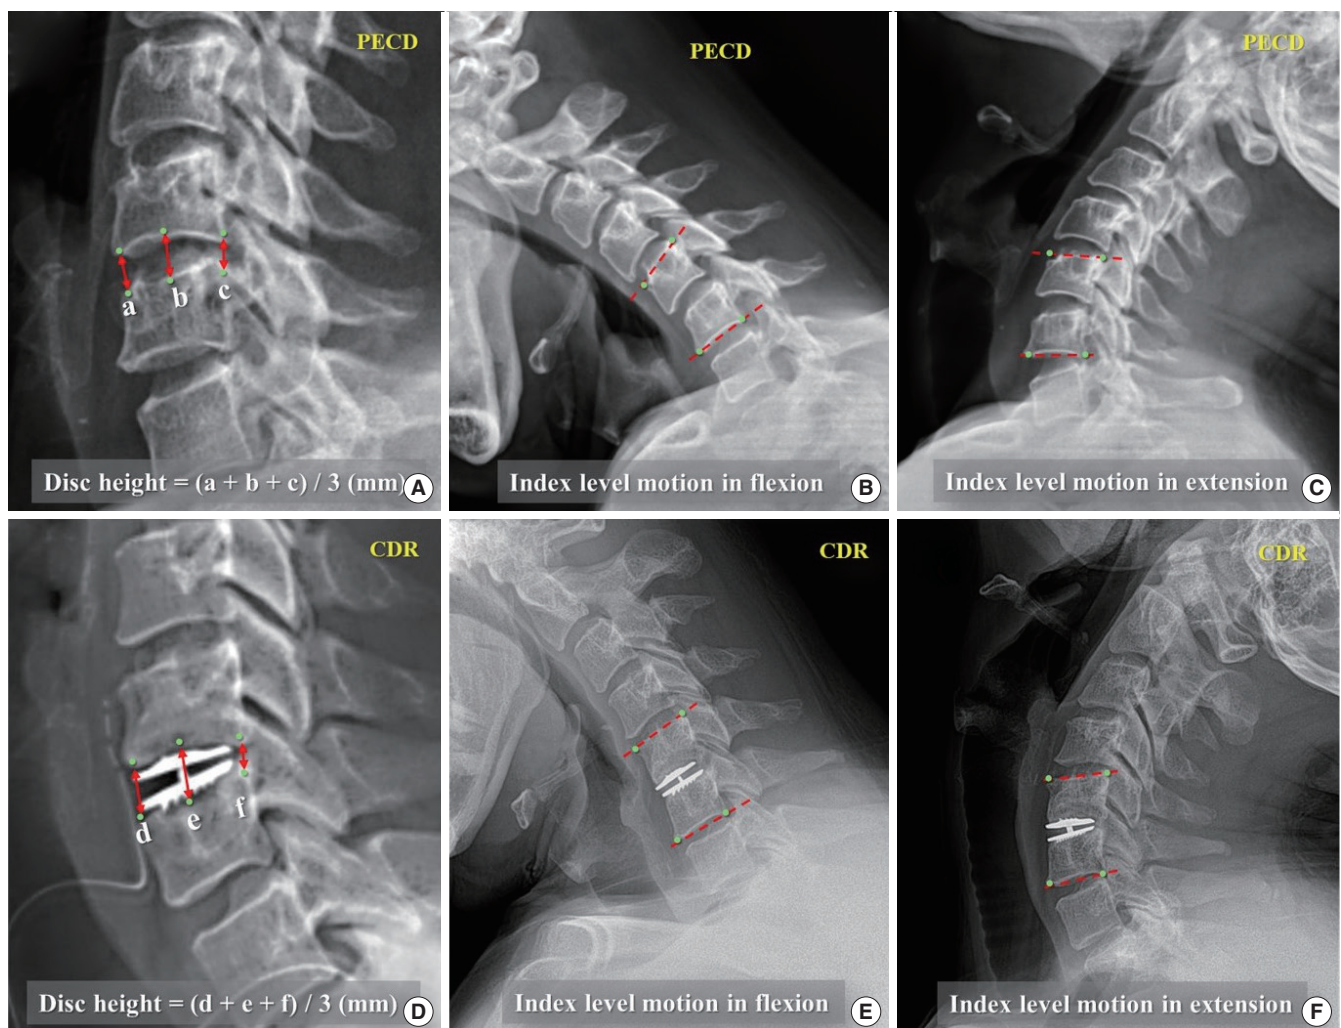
Pre- (A) and postoperative (D) cervical disc height measurements from the lateral cervical radiograph: anterior disc height (a, d), middle disc height (b, e), and posterior disc height (c, f). A preoperative disc height = $(a+b+c)/3$ (mm) and a postoperative disc height = $(d+e+f)/3$ (mm). Index level motion = Cobb angles in flexion (B, E)+extension (C, F). PECD, posterior endoscopic cervical decompression; CDR, cervical disc replacement.
